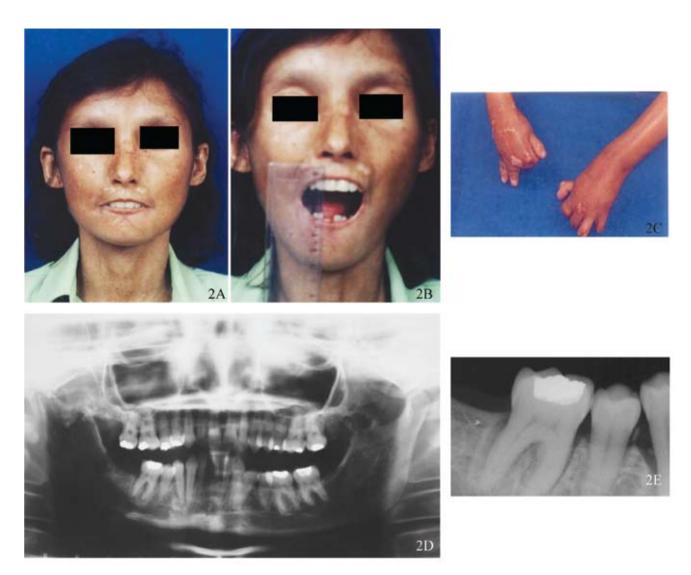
A. Involvement of the facial skin in the second patient. B. Limitation of mouth opening. C. Evidence of the tense, shiny appearance of the skin. D. Radiographs show loss of coronoid process and mandibular angle. E. Enlargement of periodontal space on molar.
